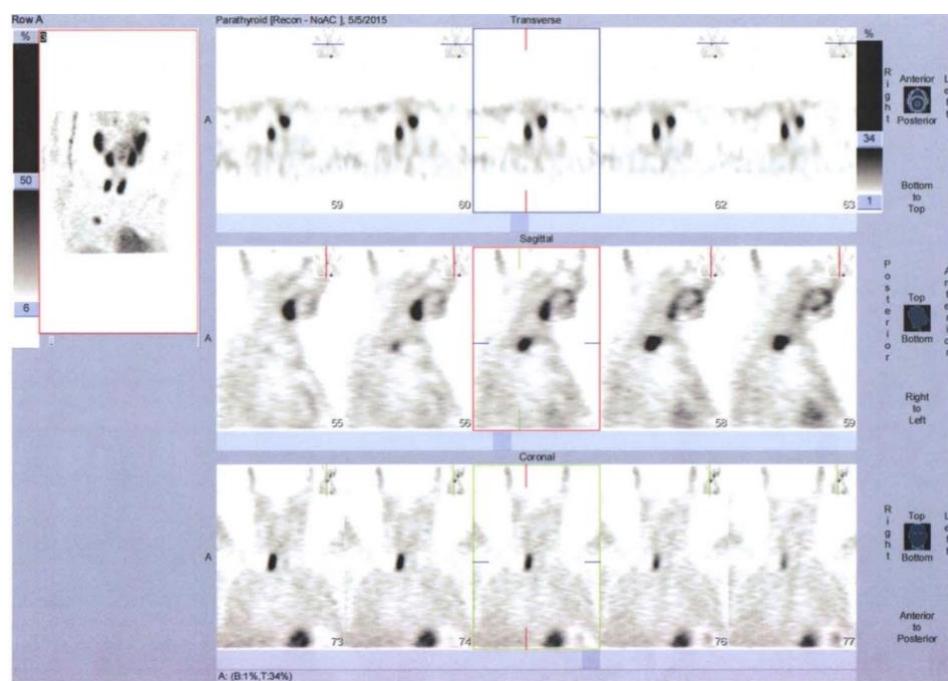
SPECT images showing an area of hyperfixation, located dorsally and caudally of the right thyroid lobe
